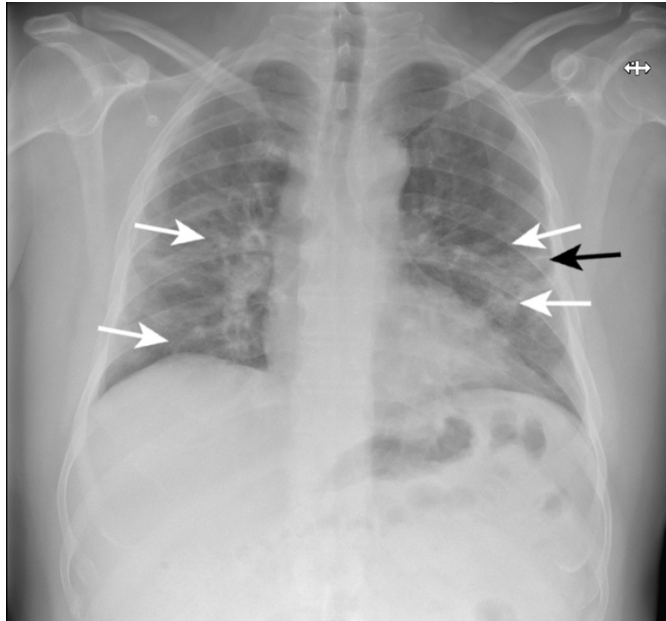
Posterior-anterior chest radiograph of a patient with COVID-19 pneumonia showing ground glass opacity in mid and lower zones of the lungs. Linear opacity observed in the periphery of the left mid zone (black arrow) and peripheral glass opacity (white arrows) with lung marking preservation (Hansell et al., 2008).
